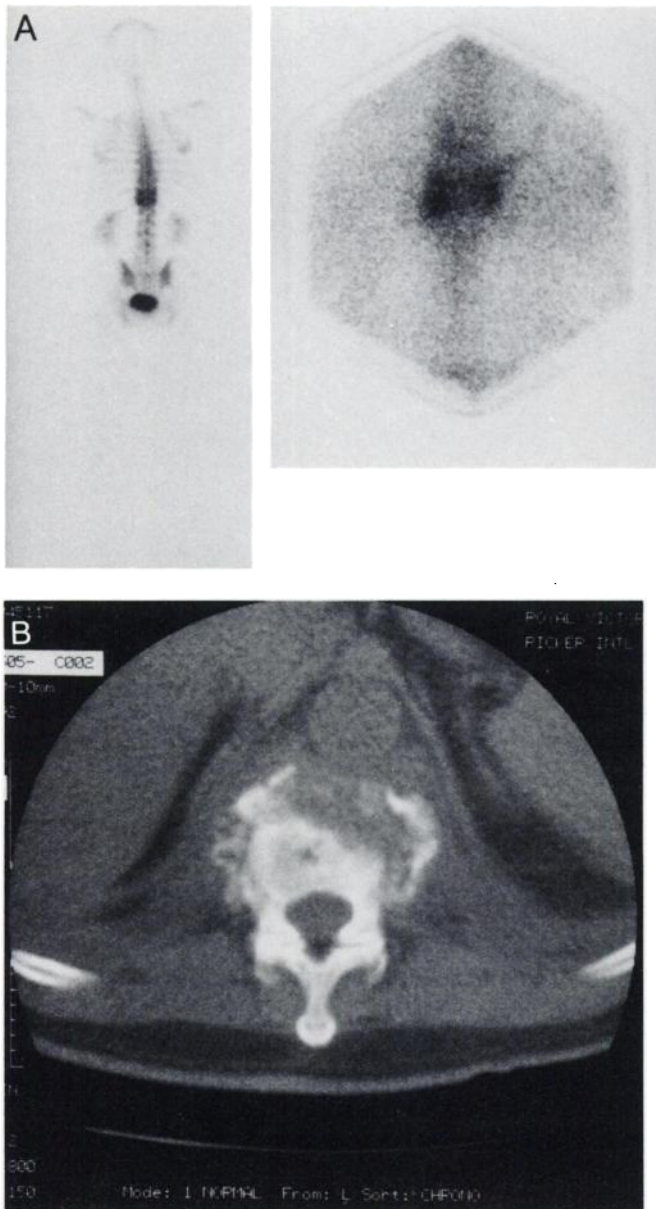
(A) A solitary lesion centered at T11-T12 is present on the whole-body bone scan. Gallium scintigraphy of that site reveals the infectious nature of the process in the vertebrae and overspill of the infection into the paraspinal soft tissues. (B) Confirmatory destructive changes at T11-T12 are seen on the CT scan, which also documents swelling of the soft tissues surrounding the spine.
